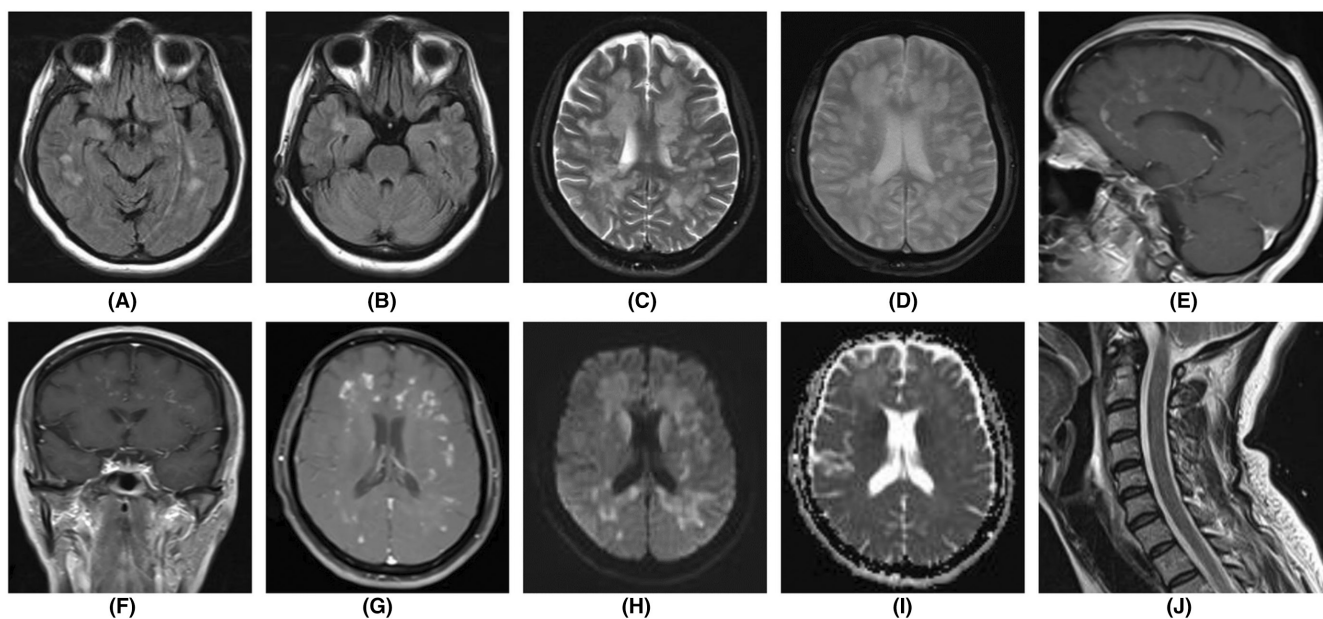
Brain and cervical magnetic resonance imaging of the case. Axial plane fluid-attenuated inversion recovery (FLAIR) (A, B); axial plane T2 (C); axial plane gradient-recalled-echo (GRE) (D); sagittal plane (E), coronal plane (F), and axial plane (G) T1 with contrast; diffusion-weighted imaging (DWI) (H) and apparent diffusion coefficient (ADC) (I) multiple confluent bilateral high-signal white matter lesions in frontoparietal lobes and corpus callosum with peripheral edema and restriction, in addition to nodular and partial ring-enhanced lesions after contrast administration with distinct oval shapes and perpendicular orientation to the lateral ventricle; sagittal plane T2 (J) normal cervical spine.
